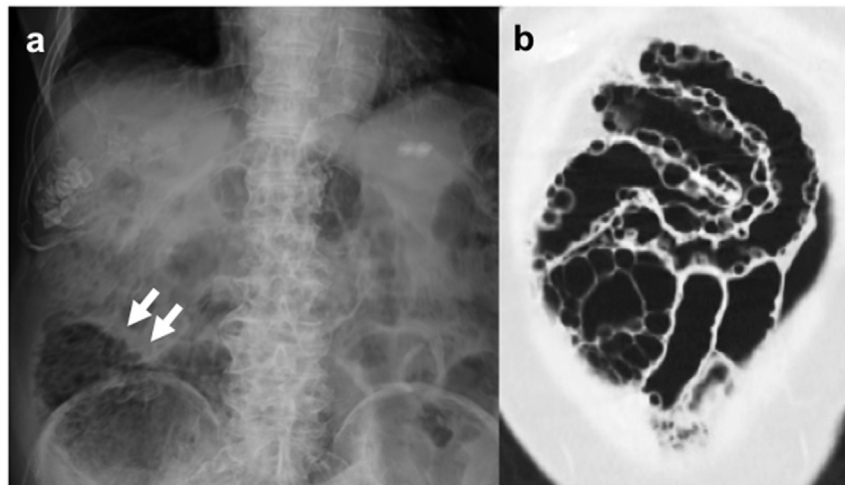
a Plain abdominal radiography and b Computed tomography images, lung-window setting (coronal). Radiolucent shadows (a, arrows) in the intestinal lumen and multiple air pockets (b) in the intestinal wall were detected before diagnostic laparoscopy.
